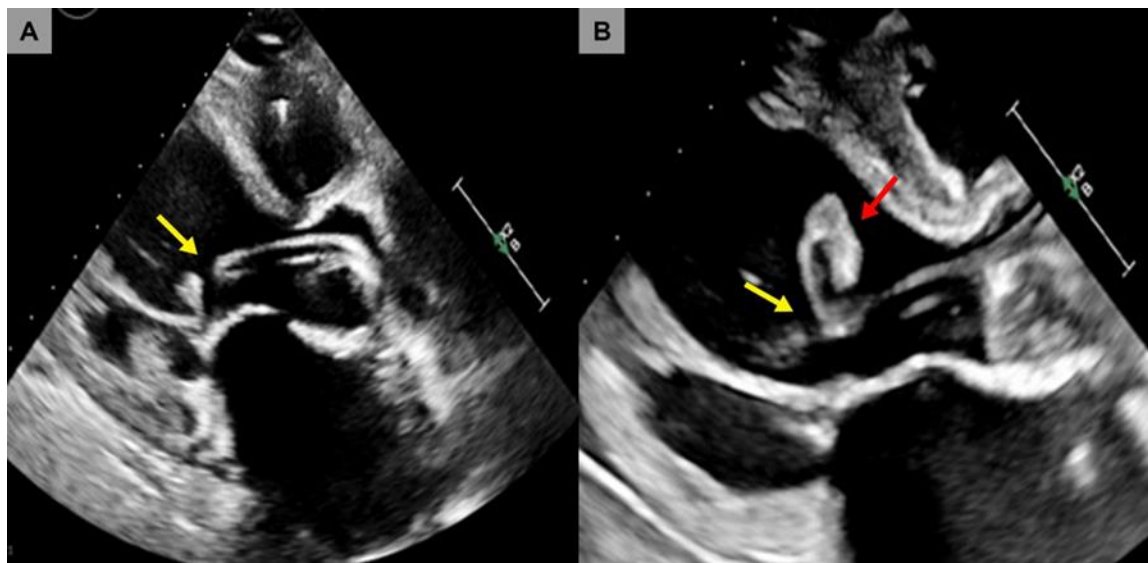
Echocardiogram ten days apart. (A) Initial echocardiogram. (B) Echocardiogram ten days later. Yellow arrows point to the Impella inlet. Red arrow points to acutely ingested thrombus.
